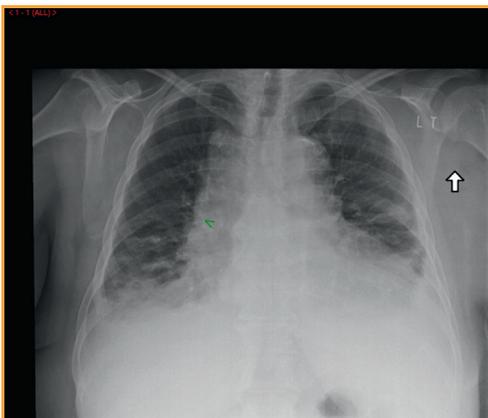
Chest radiograph at presentation showing cardiomegaly, pulmonary congestion, and small bilateral effusions. Note the widening of the mediastinum.
